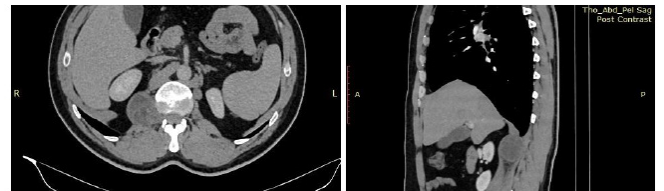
A CT scan reveals an isodense circumscribed mass with smooth, well-defined margins that extends through the intervertebral foramen, with both intraspinal and extraforaminal components, displacing right nerve roots. There were no bone erosions or remodeling detected.
